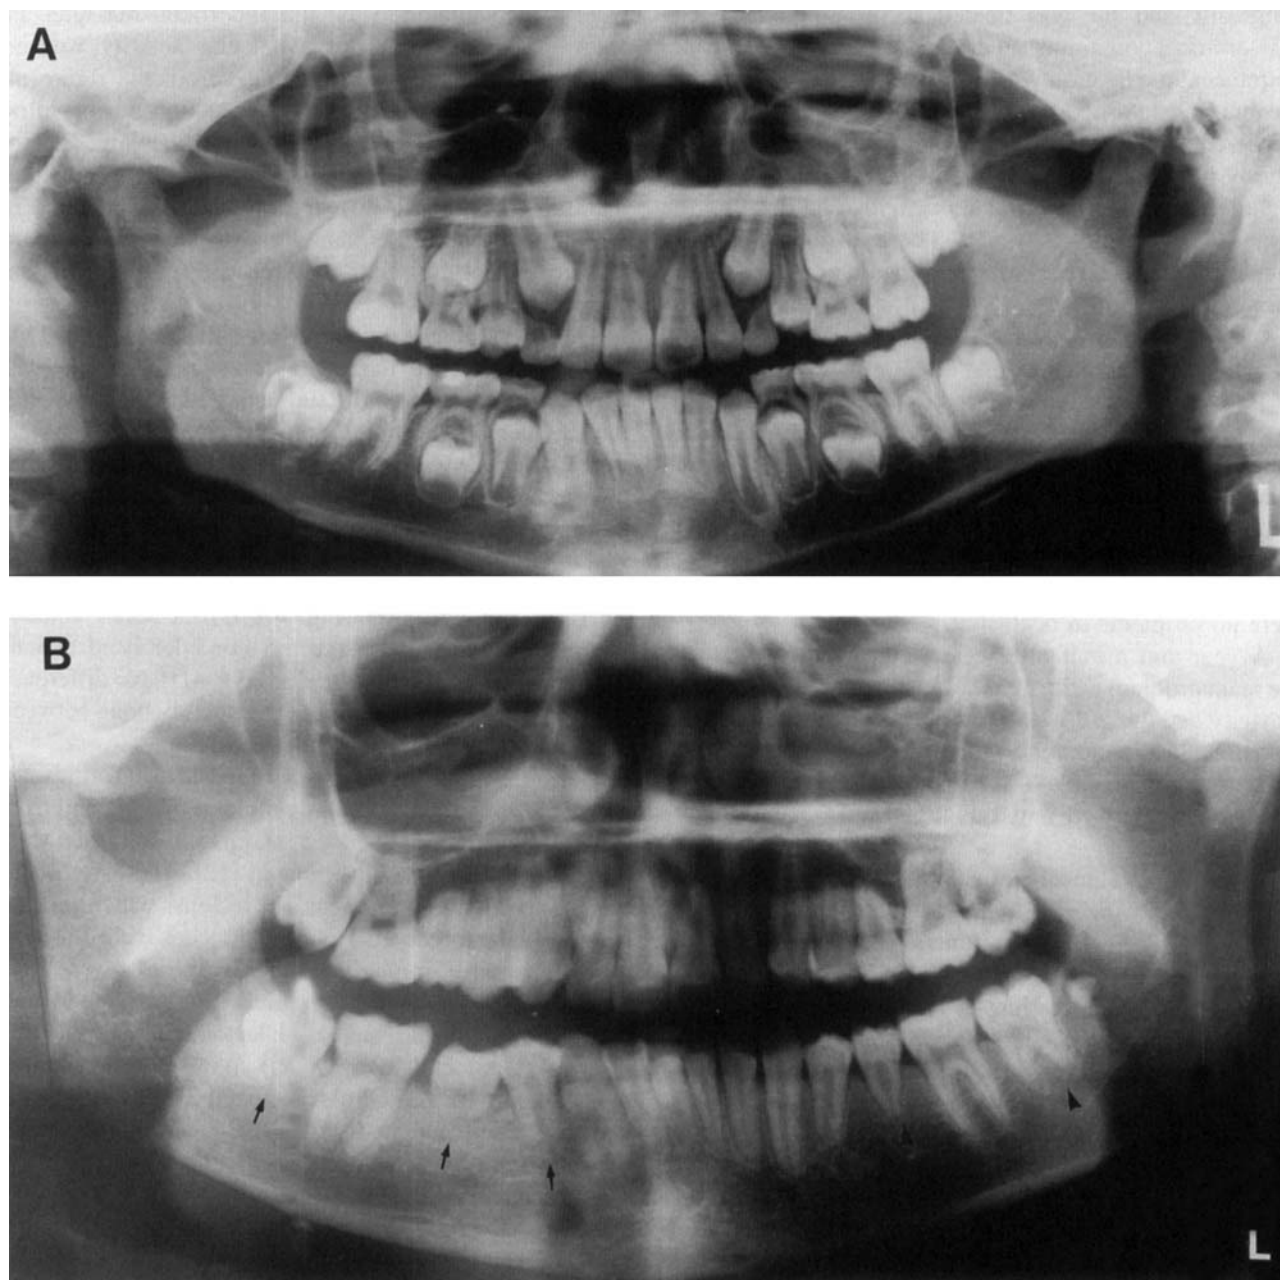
Panoramic radiographs. A: At cancer diagnosis. All teeth are developing in a normal way. B: Three years after irradiation therapy, a shortened ramus and larger gonial angle on the right than on the left side are seen. The development of premolars and second molars is more disturbed on the right side with irradiation of 50 Gy (arrows) than on the left side with irradiation of 15–18 Gy (arrowheads).
